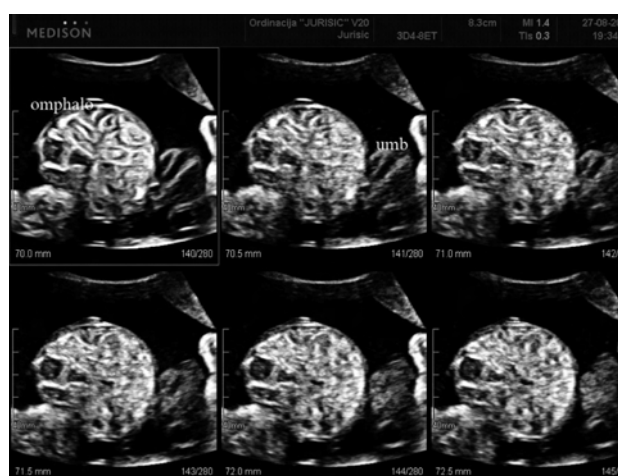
Omphalocele – 2D/3D multislice ultrasound.
